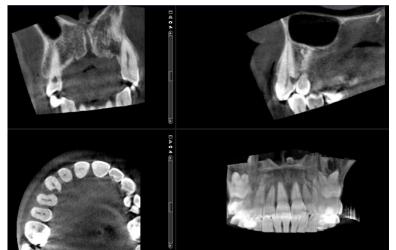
Diagnostic CBCT
